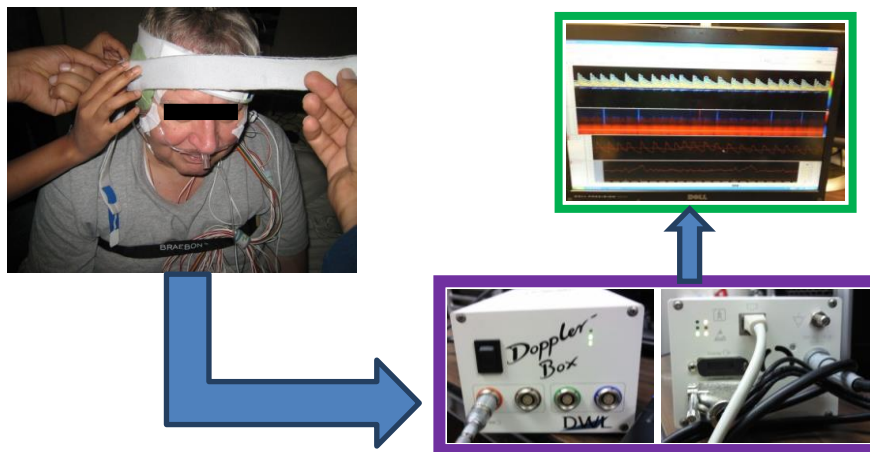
Doppler Ultrasonic Monitor and Sensor Attachment
